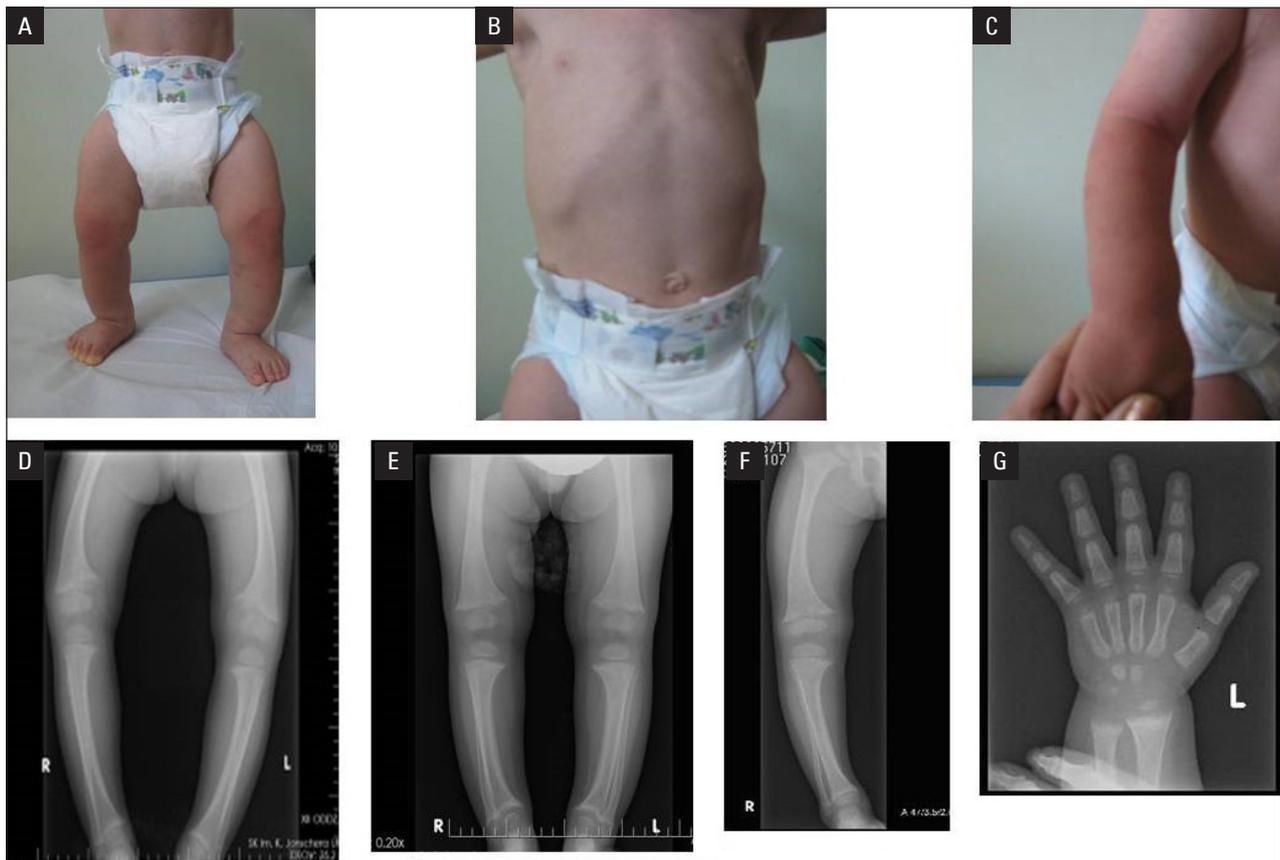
Characteristic symptoms of rickets in the presented patients. Bowing of the lower limbs (A), deformation of the chest (B) and widening of the distal parts of the forearms (C) in Patient No. 5; X-ray of the lower limbs of Patient No. 1 (D), Patient No. 3 (E) and Patient No. 4 (F) at diagnosis, with characteristic bowing of the lower limbs and distal flaring of the long bones; X-ray of the left hand of Patient No. 3 with characteristic widening of the distal parts of the forearms (G)
